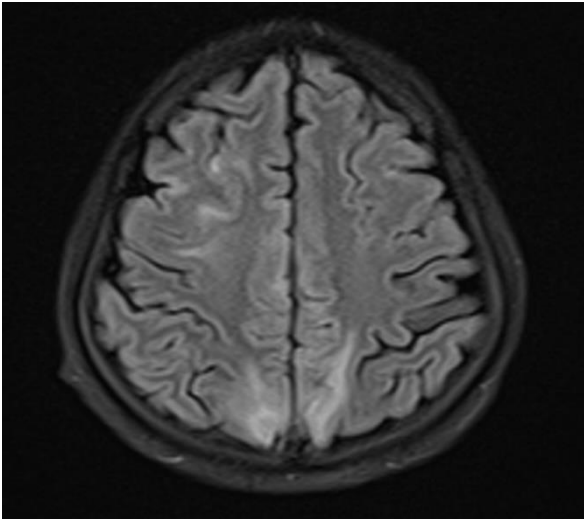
MRI brain T2 FLAIR sequence suggestive of hyperintense signal located in bilateral occipital lobe suggestive of oedema
